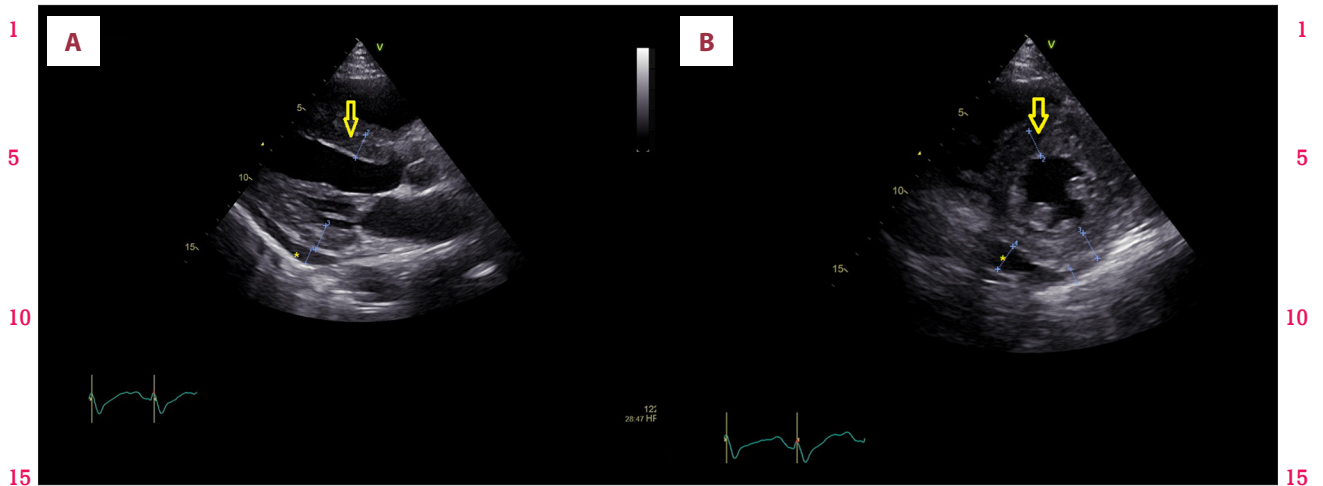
Transthoracic echocardiogram parasternal long axis view at admission showed thickened interventricular septum (arrow) and pericardial effusion at posterior (asterisk) (A). Short axis view showed thickened interventricular septum (arrow) and pericardial effusion at inferior and posterior (asterisk) (B).
